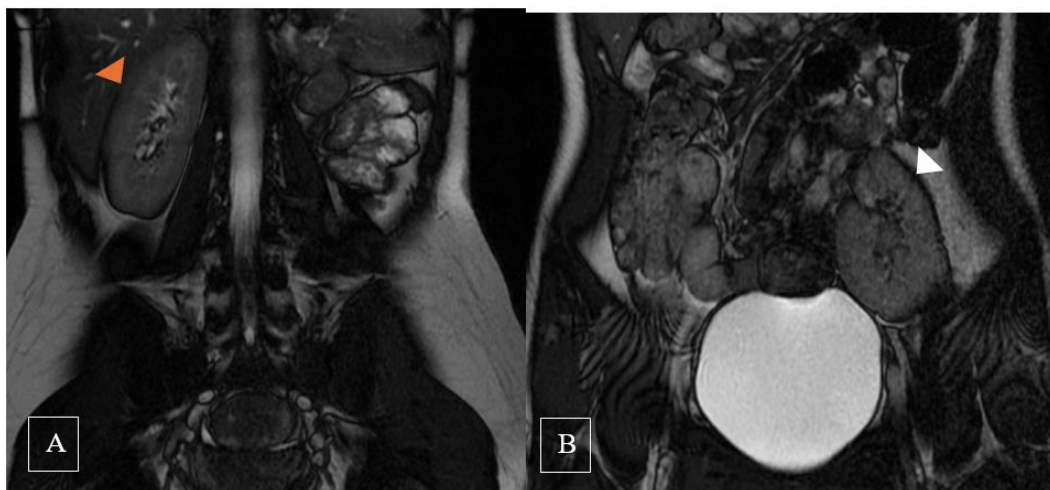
(A, B) Coronal 2D FIESTA MRI images from Case 2. (A) shows the right kidney in a normal lumbar position (orange arrowhead), and (B) shows the left kidney ectopically located in the pelvis (white arrowhead)
